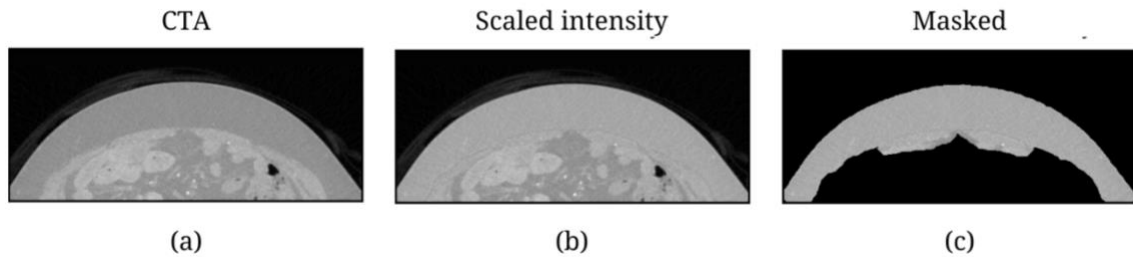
Intensity scaling of subcutaneous fat tissue to the median intensity value of rectus abdominis muscle in an abdominal CTA. Scans viewed in the axial plane. (a) Original CTA scan; (b) Scan after scaling intensity in subcutaneous fat tissue; (c) Scan masked to subcutaneous fat, muscle tissue, and the dilated region around muscle tissue.
